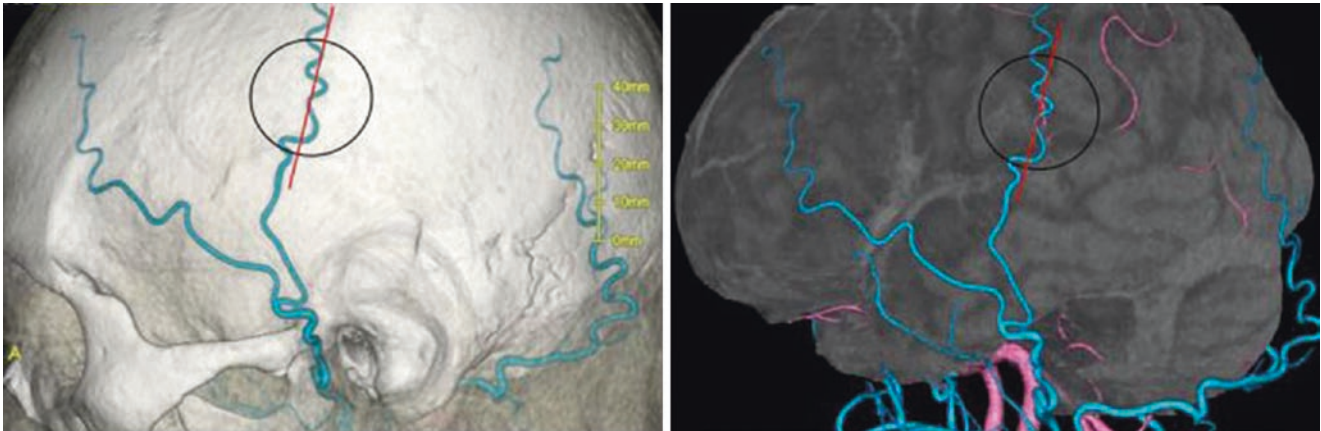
The original image of a 3D CTA demonstrates a parietal branch of the STA within the scalp and a cortical artery on the brain surface. The most suitable segments of both the artery provided as the donor (arrow) and the recipient arteries (arrowhead) for EC-IC bypass are demonstrated. The distance between the above-mentioned segment of the donor artery and the superior border of the helix can be calculated
